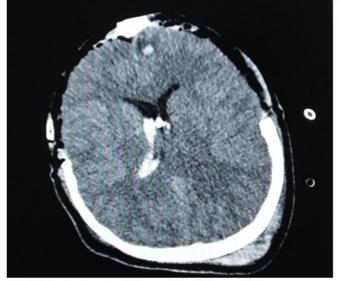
CT brain showing mild cerebral herniation after DC
